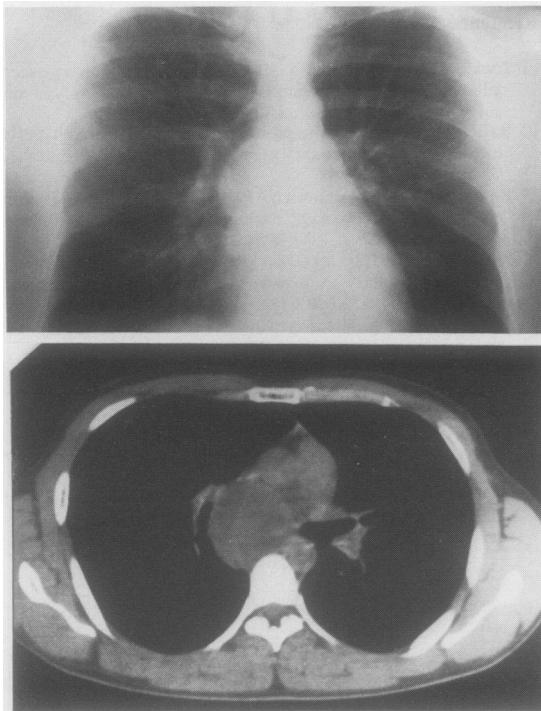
Initial chest radiograph and computed tomogram before transcarinal needle aspiration, showing a fluid density subcarinal cyst displacing and compressing the right mainstem bronchus and intermediate bronchus.
